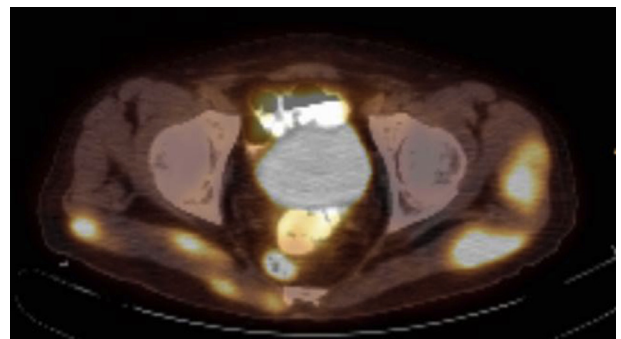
PET-CT scan of pelvic region.
